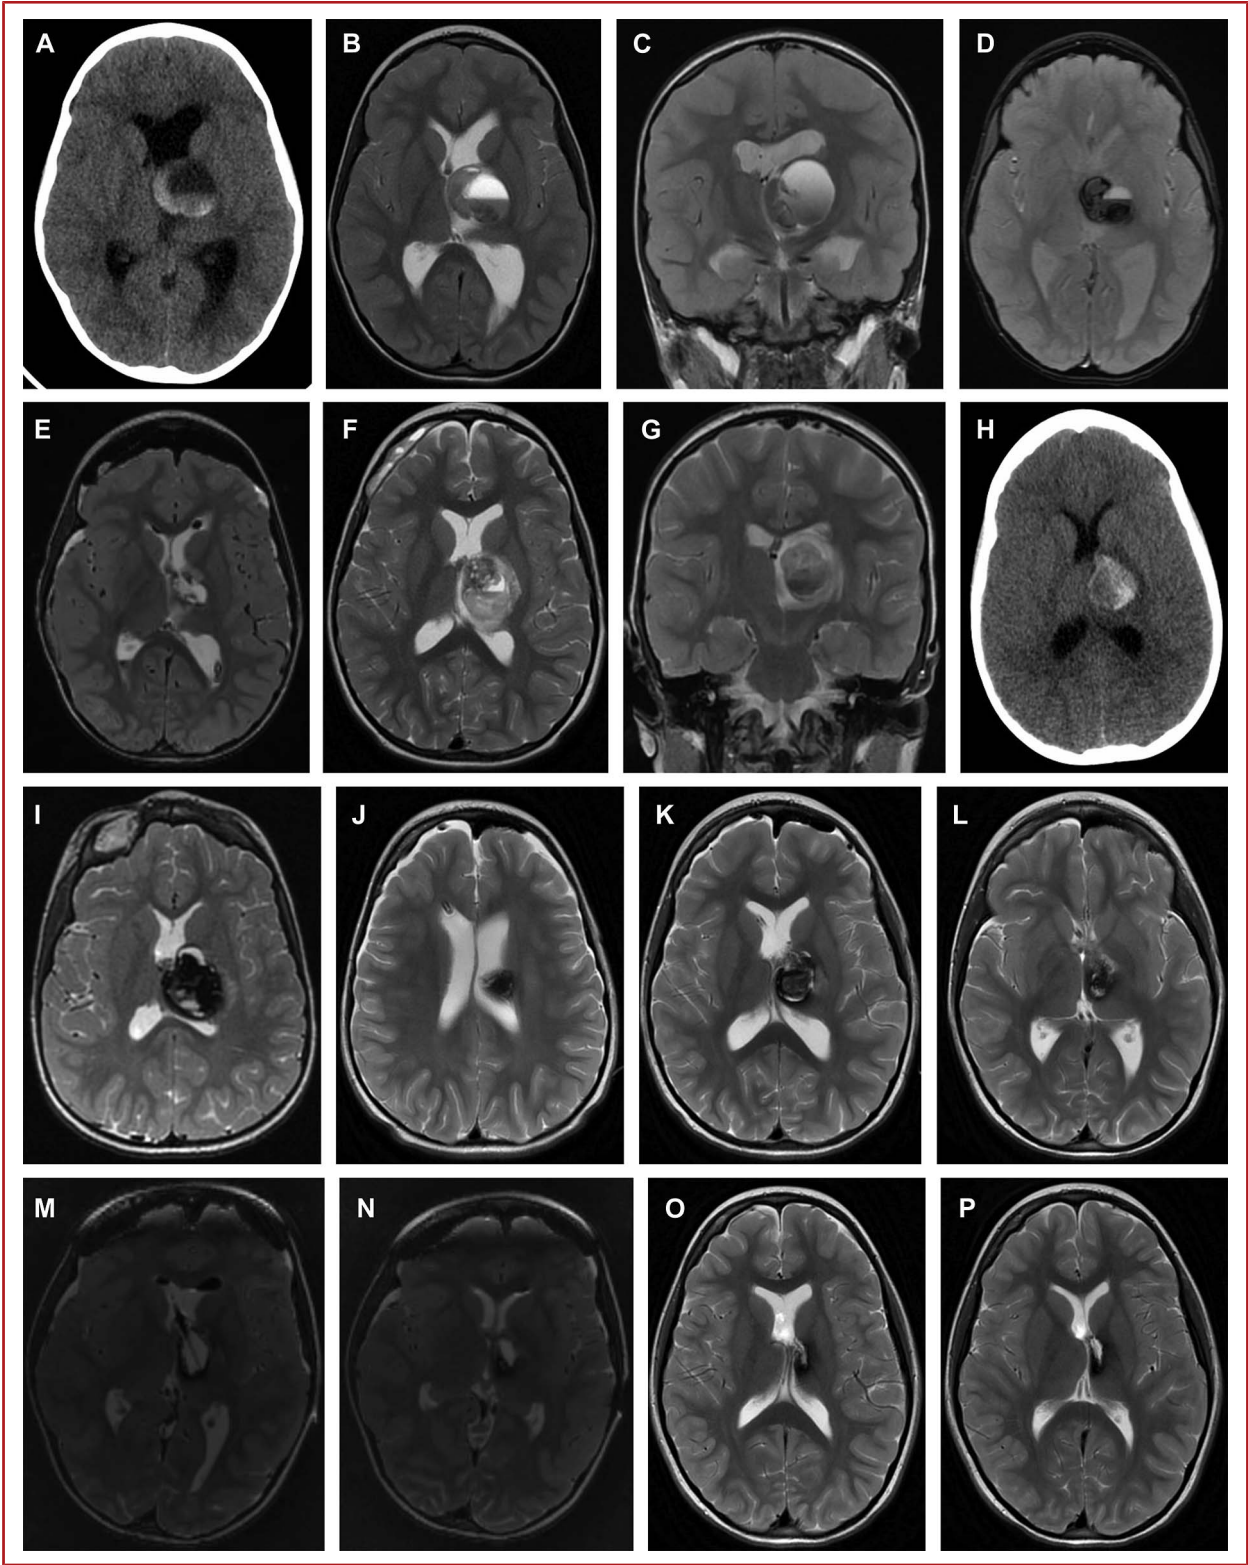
A 4-year-old girl with a hemorrhagic left thalamic cavernous malformation. A, Axial head CT, B and C, axial and coronal T2-weighted, and D, axial gradient echo images at the time of clinical presentation. E, Postoperative axial T2-weighted MRI demonstrating resection cavity. F and G, Routine surveillance axial and coronal T2-weighted MRI at 1 month after surgery demonstrating recurrent hemorrhage and mass effect. H and I, Axial head CT and T2-weighted MRI 10 months after initial craniotomy when patient returned with acute headache and vomiting, demonstrating acute left thalamic hemorrhage with perilesional edema and mass effect. J-L, Axial T2-weighted MRI obtained postoperatively (ie, after second resection) demonstrating interval debulking but residual cavernoma in the left thalamic region. The patient was taken back to the operating room 5 days later for complete resection of residual cavernoma, as demonstrated in intraoperative axial T2-weighted images in M and N. O and P, Last available surveillance scan obtained 18 months after initial presentation continues to demonstrate no residual lesion on axial T2-weighted MRI. The patient's guardians consented to the publishing of these deidentified radiographic images. CT, computed tomography.
